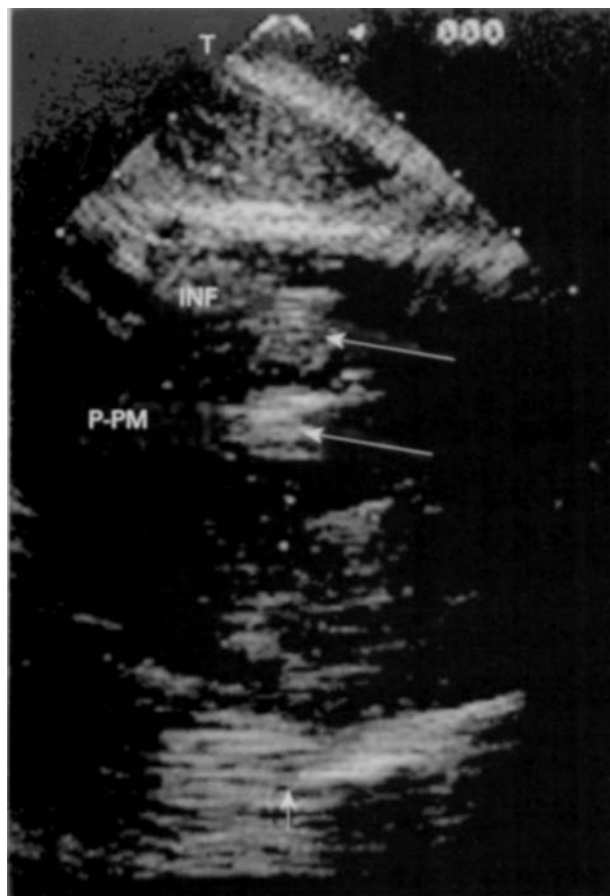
Transoesophageal echocardiogram showing echogenic dots (arrows) in the inferior wall (INF) and posteromedial papillary muscle (P-PM).
